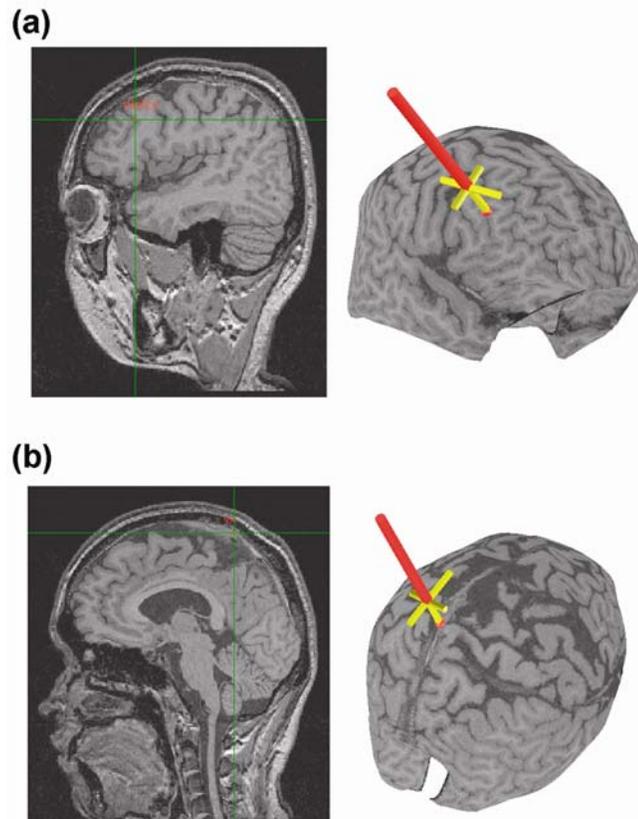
TMS targeting with frameless stereotaxy. The TMS coil was located over (a) the right DL-PFC ($X=45$ $Y=33$ $Z=25$) or (b) the vertex (control) ($X= 0$ $Y= -35$ $Z= 80$). Positioning of the TMS coil over these locations, marked on the native MRI, was performed with the aid of a frameless stereotaxic system.
